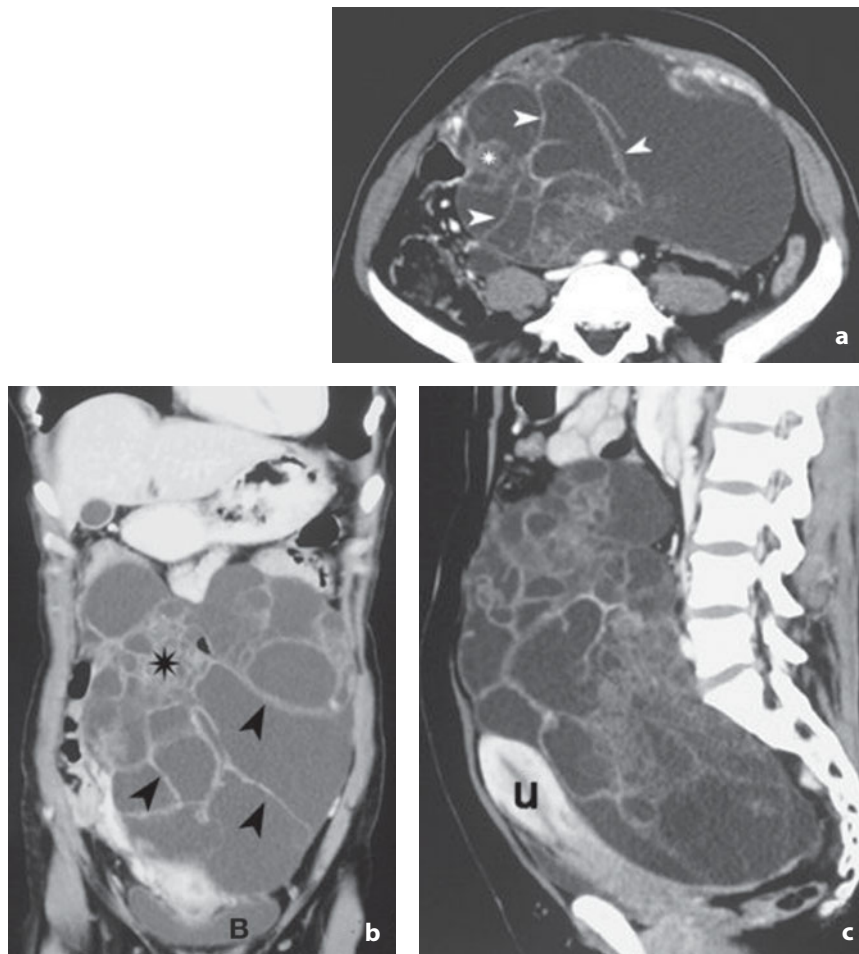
Computed tomography. Serous adenocarcinoma. a Contrast-enhanced examination. Large mixed-composition lesion with fluid component containing irregular septa (*arrowheads*) and enhancing solid component (*asterisk*). The coronal (b) and sagittal (c) reconstructions show the mass extensively occupying the abdomen. *U*, uterus; *B*, urinary bladder
